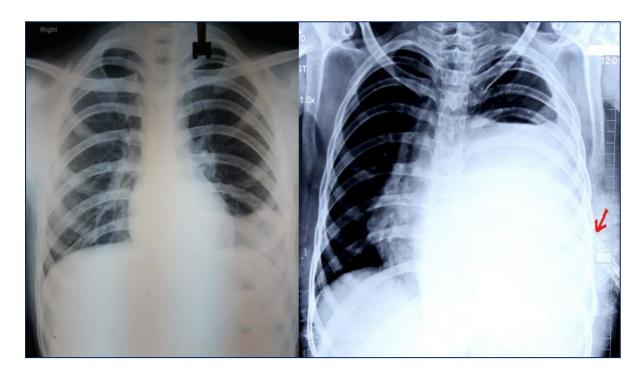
A) Initial chest radiograph showing opacity in left lower lobe; B) chest radiograph showing a large homogenous opacity in the left hemithorax with ICD *in situ* (red arrow).
